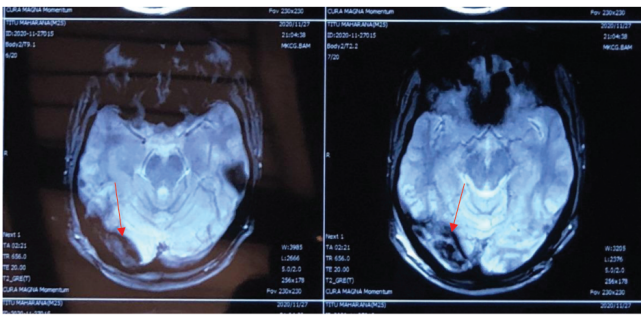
MRI brain T2 wightedimage showing no flow along the right transverse sinus suggestive of thrombosis. (red arrows)
